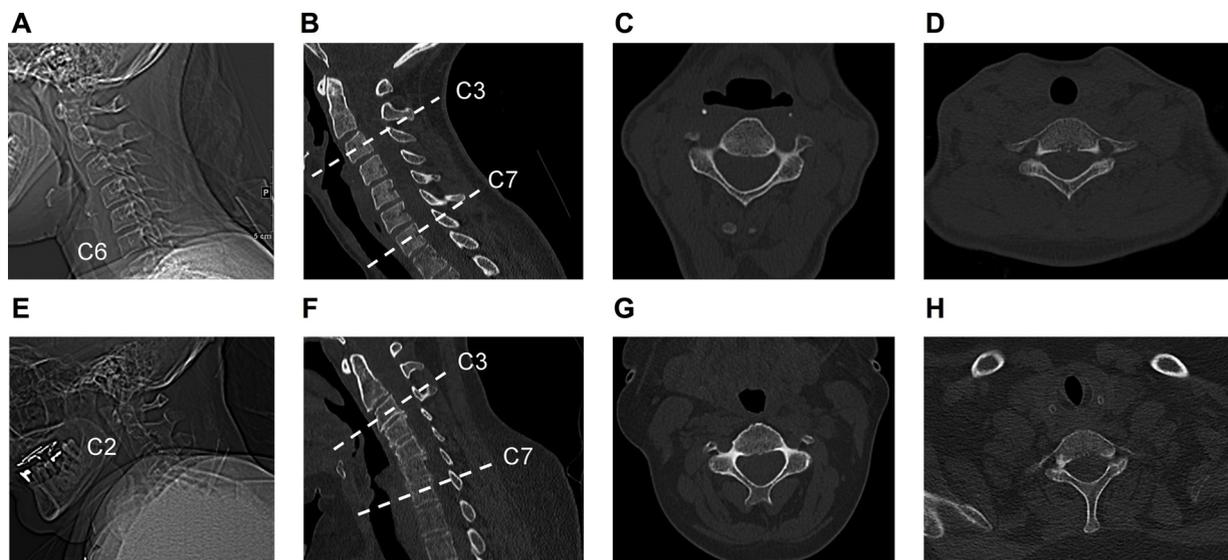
CT of the C-spine in two different patients performed with the dose-optimized protocol of 105 mAs (A–D) and with the standard protocol of 195 mAs (E–H). Lateral topograms display a shoulder level below C6 (A) for the dose-optimized protocol and below C2 (E) for the standard protocol. Sagittal (B and F) and axial (C, D and G, H) reformatted images with sinogram-affirmed iterative reconstruction (SAFIRE, strength level 3) using bone convolution kernels (window level/width, 600/2000) show that image noise and quality is superior at the lower C-spine level with a dose-optimized protocol and capability of shoulder pull-down (A–D) as compared to a standardized protocol and elevated shoulders (E–H).
